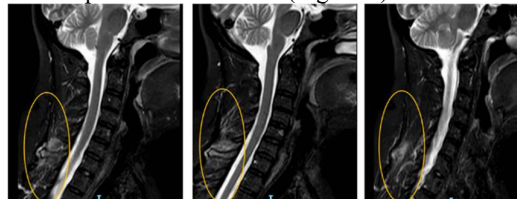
MRI of the cervical spine in STIR sequence: enthesitis of the cervical interspinous ligament (yellow circles).
